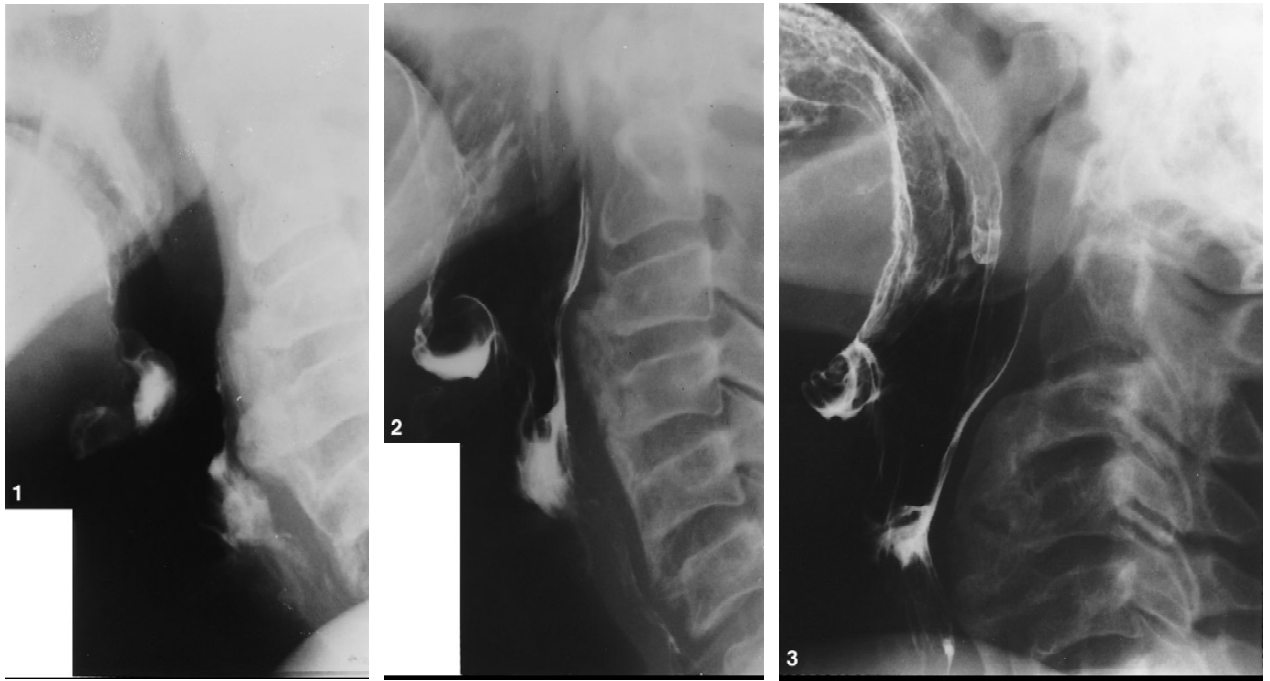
Preoperative lateral neck radiograph during modified barium swallow of Case 1 with obstructive osteophyte dysphagia secondary to medium size C3–4 osteophyte.
